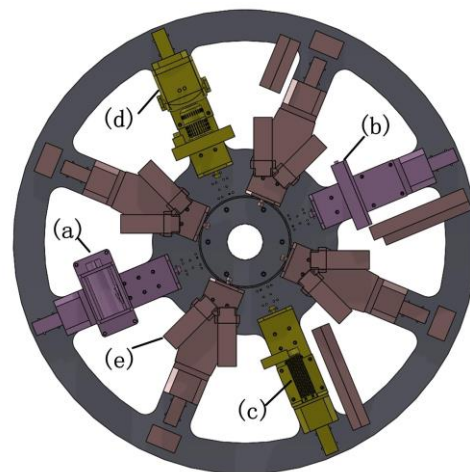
Imaging devices on the dial. (a) X-ray source. (b) X-ray flat panel detector. (c) Laser source. (d) EMCCD camera. (e) PET flat panel detector.
